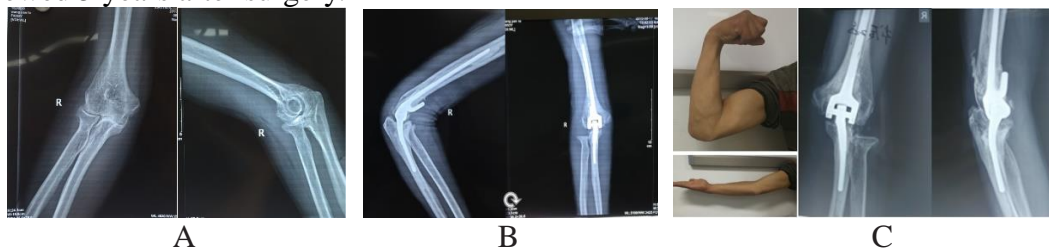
A: Anteroposterior and lateral X-ray of the affected elbow; B: Anteroposterior and lateral X-ray of the affected elbow 3 days after surgery, C: Range of motion and anteroposterior and lateral X-ray of the patient 2 years after surgery
